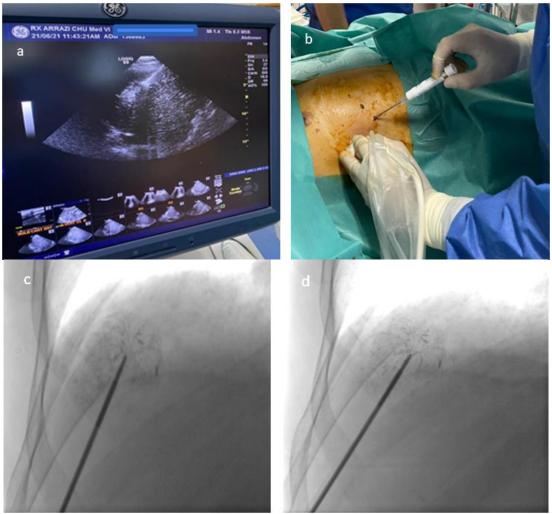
2nd stage of treatment: Biopsy + Radiofrequency: a: Under ultrasound and scopic control, placement of the coaxial at the level of the lesion of the hepatic dome; b: Intratumoral biopsy; c, d: Treatment by radiofrequency with a deployable whalebone device in two steps 180w in 15 minutes and 40w in 1 minute on the lower lesion edge
